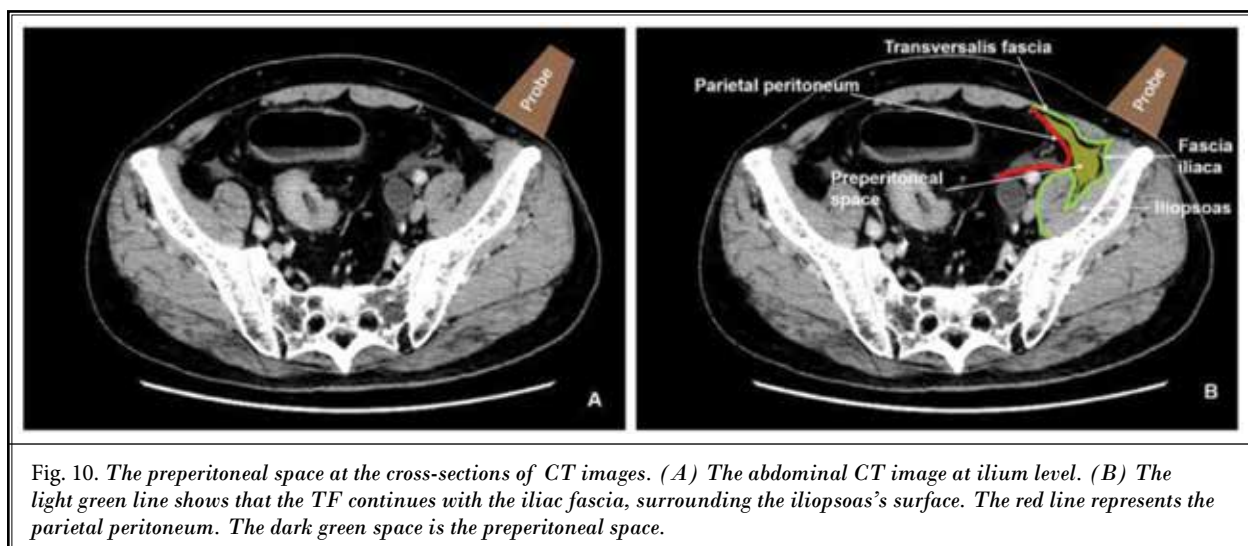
The preperitoneal space at the cross-sections of CT images. (A) The abdominal CT image at ilium level. (B) The light green line shows that the TF continues with the iliac fascia, surrounding the iliopsoas's surface. The red line represents the parietal peritoneum. The dark green space is the preperitoneal space.
